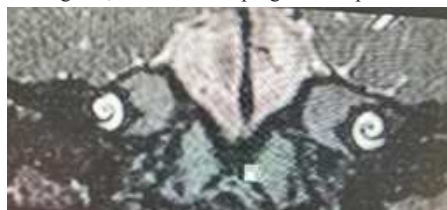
MRI CISS image show normal cochlear 2.5 turns
